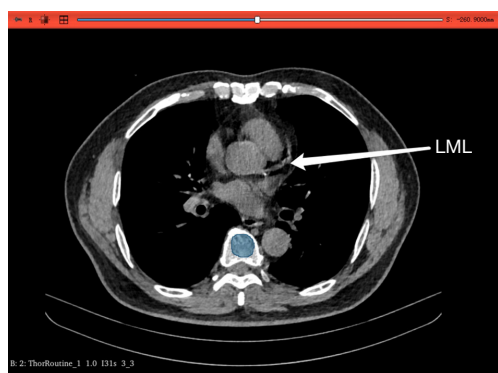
Bone mineral density measurement on thoracic quantitative CT images. The blue area in the image represents the measurement values marked on the axial section. CT, computed tomography; LML, left main coronary artery level.
